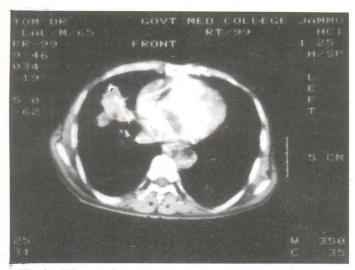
CT scan of chest (contrast) showing irregular hyperdense mass involving medial segment of right middle lobe.
